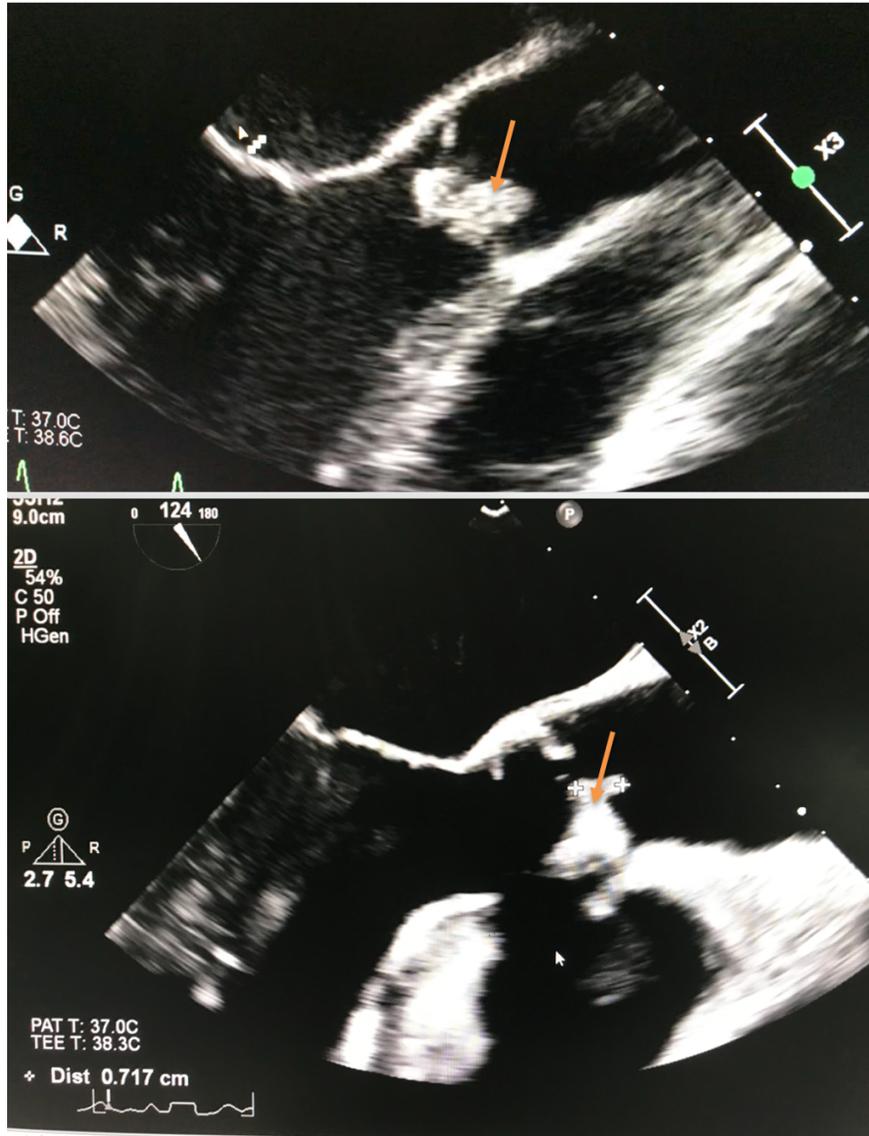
Transesophageal echocardiogram done in January 2023
